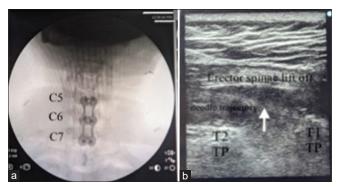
a: X-ray image of dual level (C5-C6, C6-C7) anterior cervical fusion; b: Ultrasound-guided T1 erector spinae plane block; TP = Transverse Process
